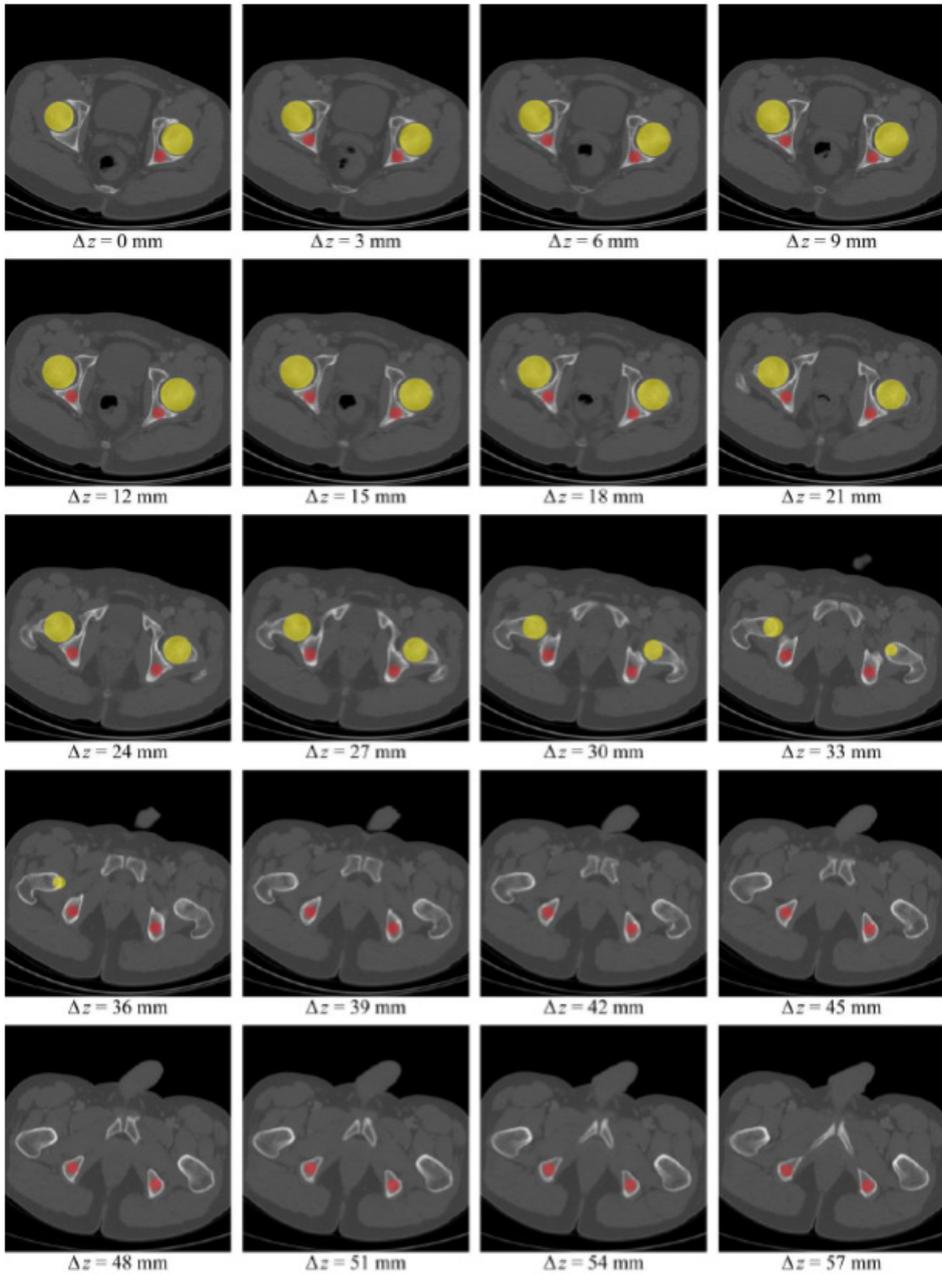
Consecutive axial CT cross-sections (Δz denotes the offset from the first cross-section) with the obtained left and right femoral heads (cross-sections of spheres, in yellow), and of the obtained left and right ischia (cross-sections of truncated elliptical cones, in red).
